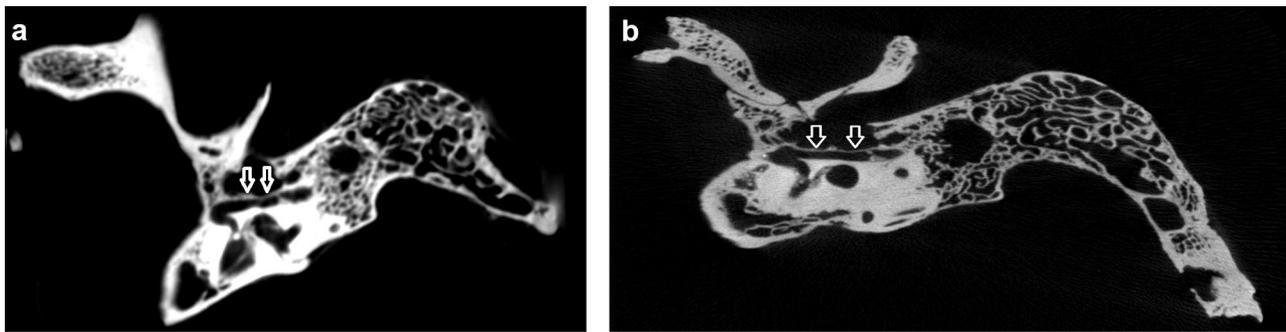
(a) CBCT view of the facial canal with intact bone structure. (Arrows show the bone structure covering the facial canal). (b) Micro-computed tomography image of the facial canal with intact bone structure of the same sample. (Arrows show the bone structure lining the facial canal)
